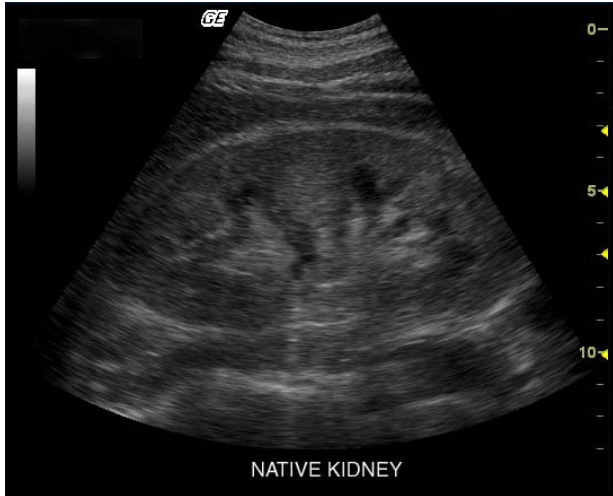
Ultrasound image of the kidney. (Permission from GE Medical, copyright © GE Medical)
